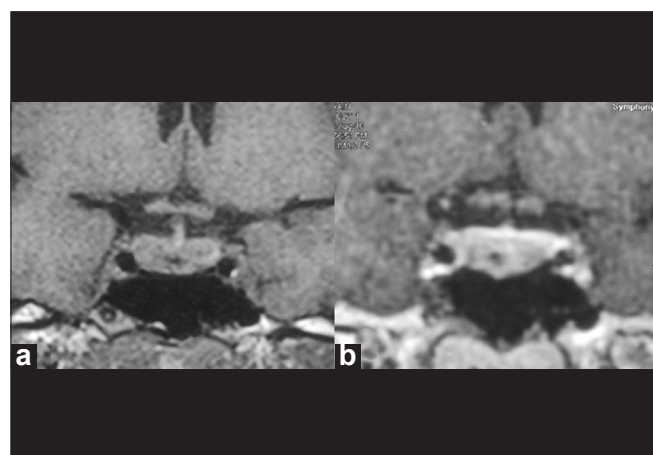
T1-weighted coronal MR image (a) pre-contrast and (b) post-contrast shows the same lesion with no enhancement
